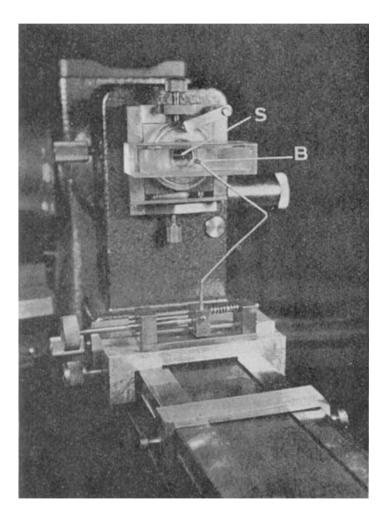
Photograph of controlled humidity cell mounted on X-ray collimator
